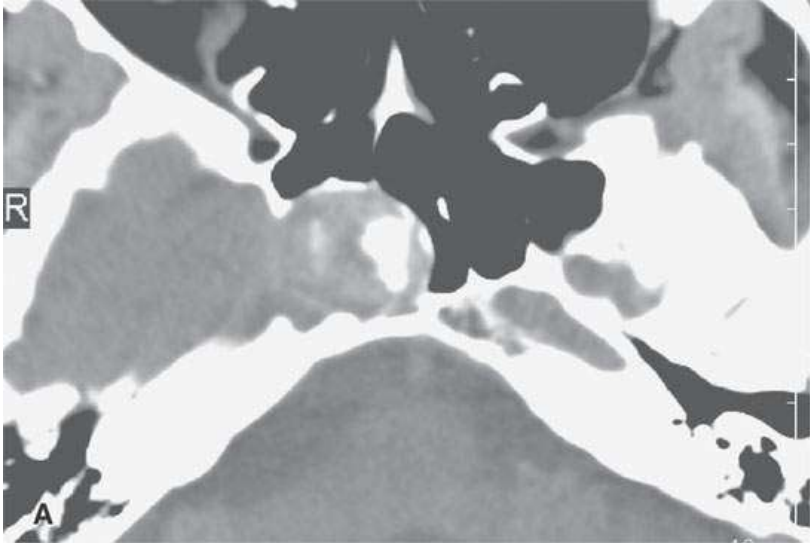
Calcified foreign bodies, A: Computed tomography (CT) of calcified surgical material that incited this chronic sinusitis left after an endoscopic sinus surgery procedure. B–E: Non-contrast-enhanced CT and magnetic resonance imaging (MRI) of a patient who had a piece of a fence post penetrate from the orbit to the deep facial soft tissues. In (B), the air pattern shows the wood. Weeks later in (C), the foreign body has mineralized. In (D) and (E), the MRI does not really provide as definitive overall evaluation of the situation, but is does nicely demonstrate the surrounding soft tissue response.
